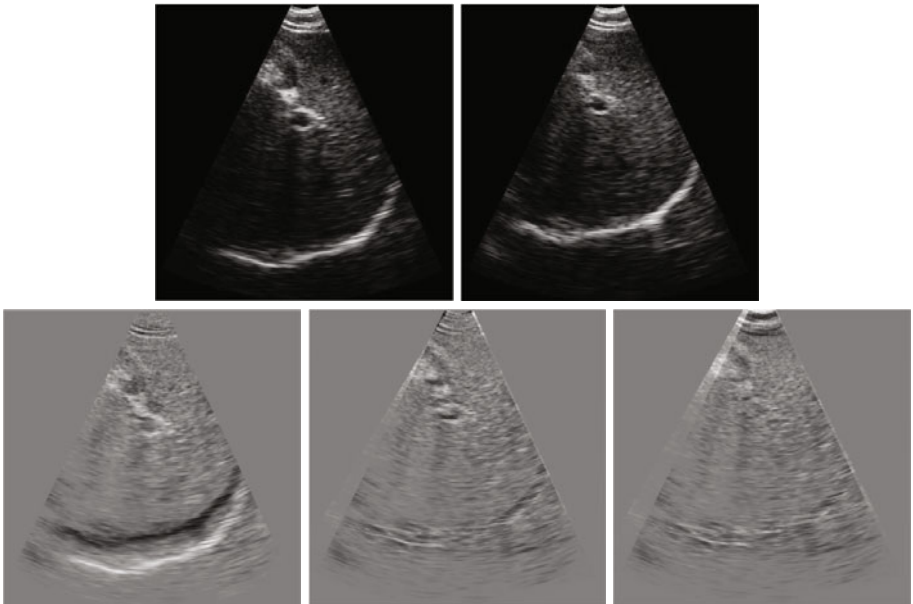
Upper left: the ultrasound frame 15 in the liver data. Upper right: the ultrasound frame 180 in the liver data. Lower Left: the rescaled subtraction of frame 180 from frame 15. Lower middle: the rescaled subtraction of frame 180 from transformed frame 15 using the result of registration. Lower right: the rescaled subtraction of frame 180 from transformed frame 15 using the result of contour tracking.
